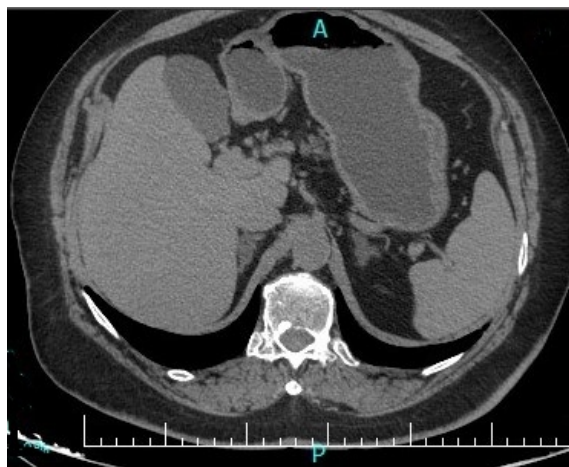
Abdominal CT findings: benign adenomas on both adrenal glands.
